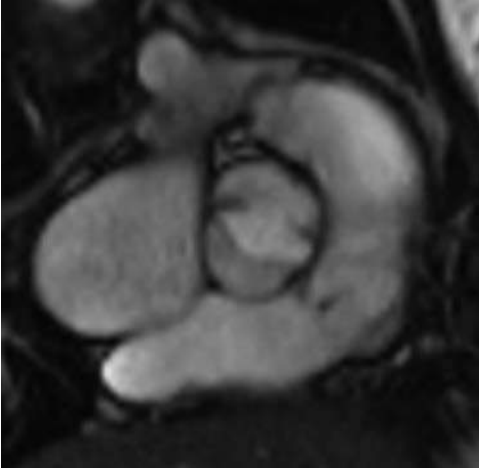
Magnetic resonance image of a bicuspid aortic valve in systole (short-axis view). (Courtesy Dr. N. Johnston.)
